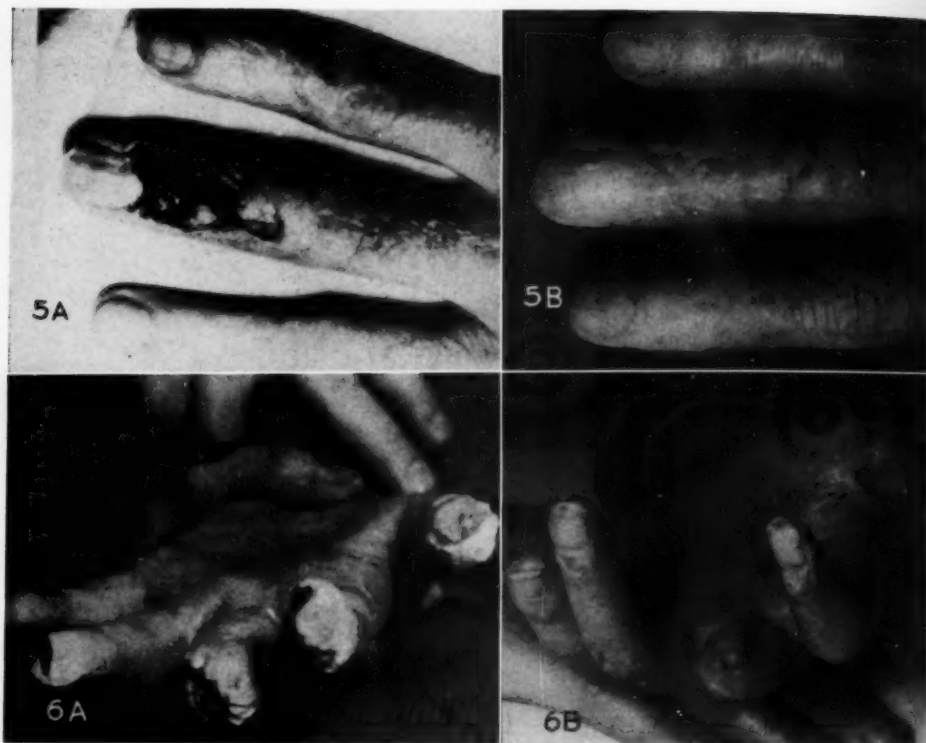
A. Roentgen injury to dorsum of left middle finger of physician, of two years' duration. B. Complete healing following seventeen weekly applications of radon ointment.
